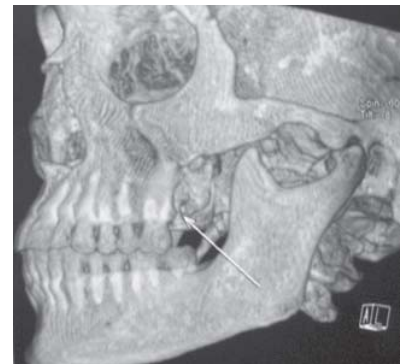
3D image CT scan shows bony involvement of the buccal cortex in second molar region
